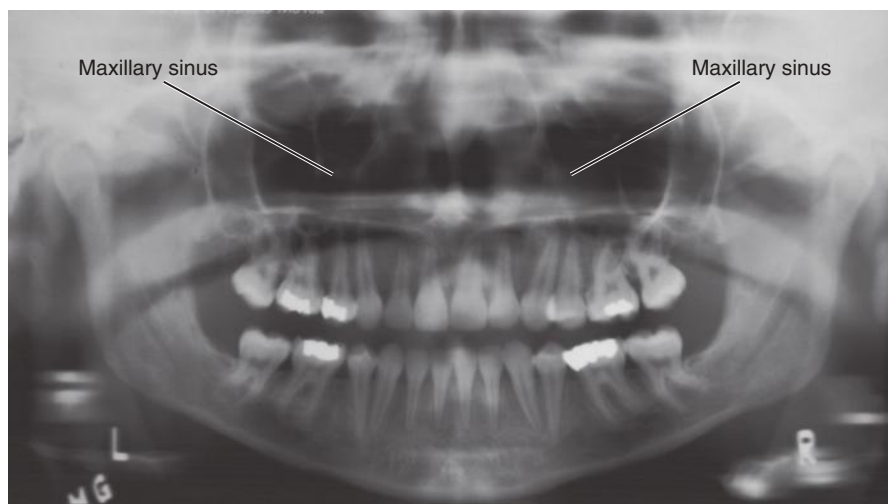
Panoramic radiograph demonstrating that the roots of the maxillary posterior teeth are in close proximity to the maxillary sinuses. (Courtesy of Margaret J. Fehrenbach, RDH, MS.)
